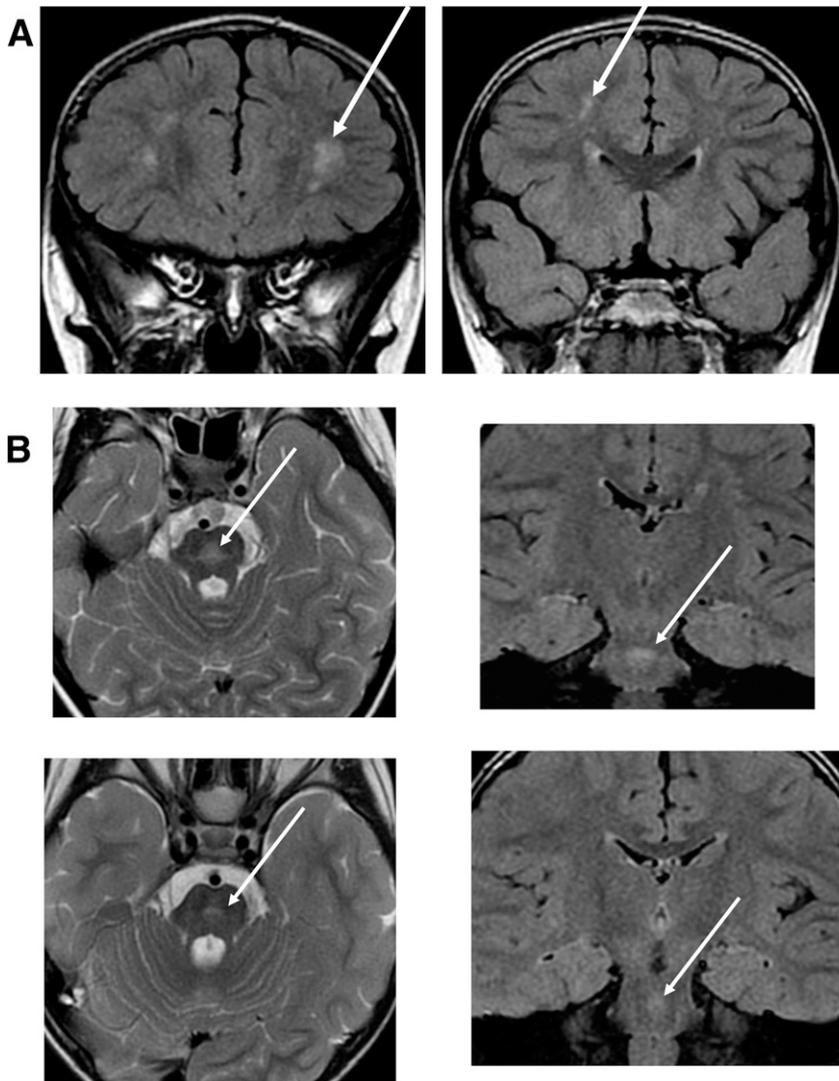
A: MRI showing multiple punctate white matter hyperintensities on coronal FLAIR sequences (arrows). B: MRI showing brain stem hyperintensities (arrows) in the nucleus raphe pontis in two different children (top images, 4-year-old patient; bottom images, 2.5-year-old patient) on axial T2 and coronal FLAIR sequences.
